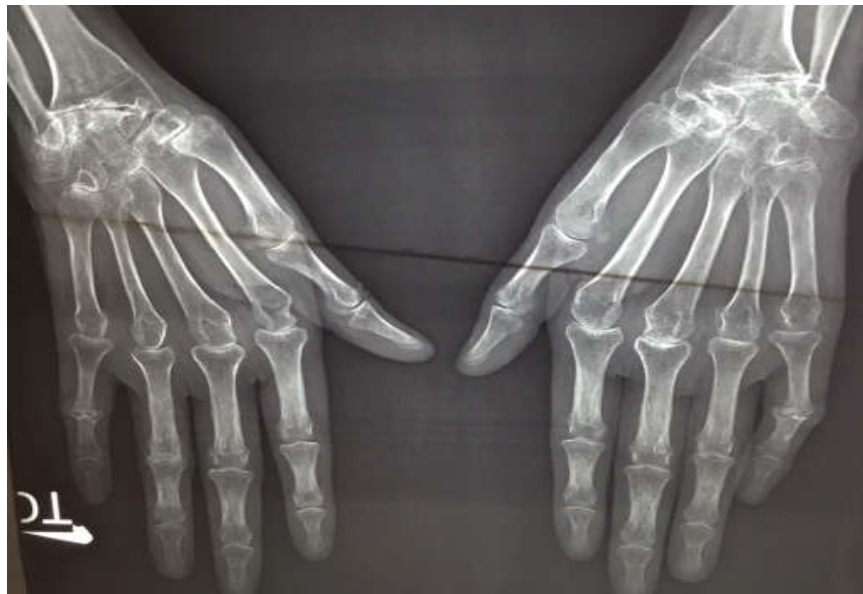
Standard X-ray of the hand in this 34-year-old patient with rheumatic manifestation of endocarditis
